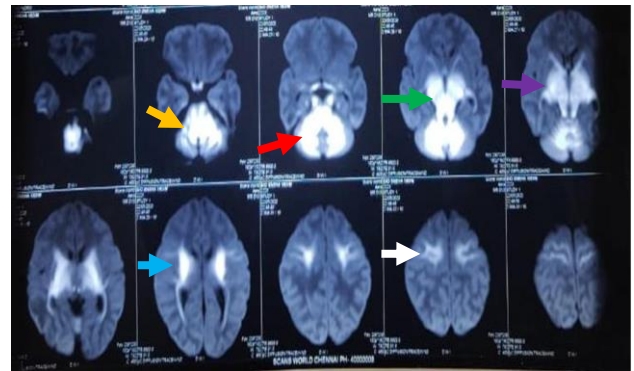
DWI axial images, diffusion restriction in bilateral perirolandic white matter (white arrow), corticospinal tracts (green arrow), corona radiata (blue arrow), thalamo-ganglionic region (purple arrow), brain stem (yellow arrow) and deep cerebellar white matter (red arrow).
